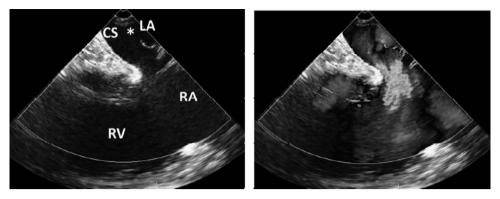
Transcophageal echocardiography demonstrates the communication between left atrium and dilated coronary sinus. Color Doppler imaging reveals shunt flow from left atrium to right atrium through the unroofed coronary sinus. LA = left atrium; CS = coronary sinus; RA = right atrium; RV = right ventricle.
